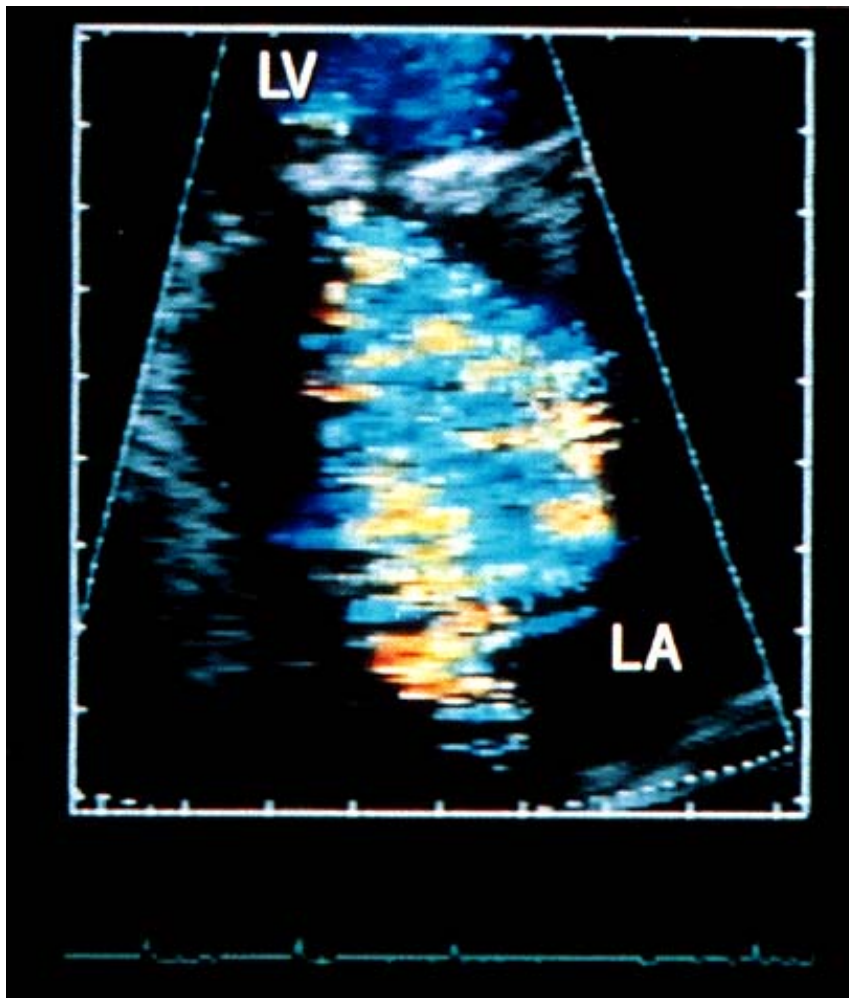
(Plate 92) Color flow imaging of a central jet of a functional mitral regurgitation by transthoracic echocardiography. Note that the jet is free, expands in the left atrium, and tends to overestimate this moderate regurgitation.
